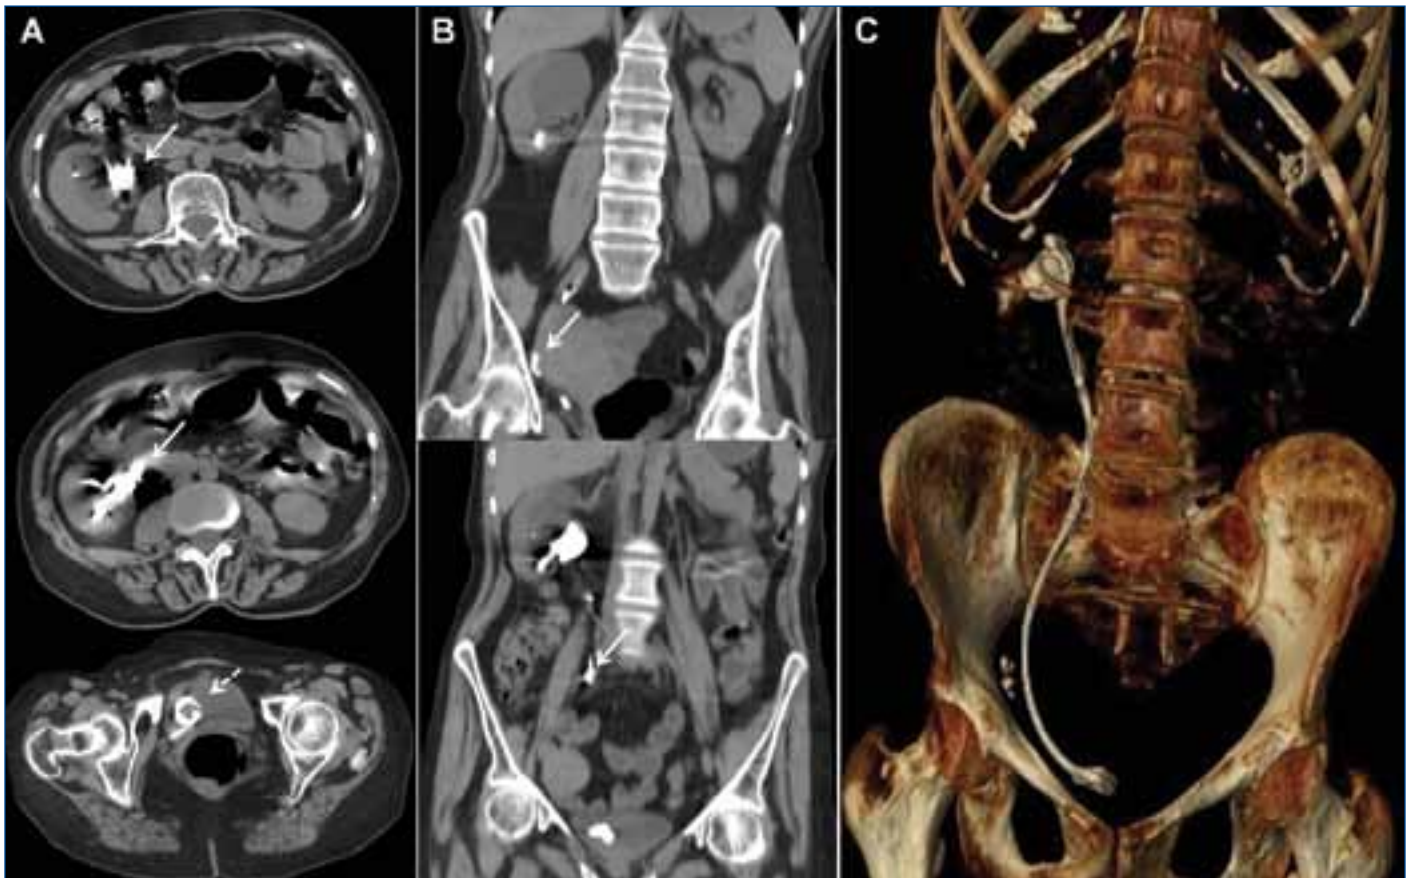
Non-contrast computed tomography accurately evaluate the extent of double J encrustation; A – Axial view depicts significant stone burden associated with the forgotten stent in the kidney and ureteropelvic junction (straight arrow) with less encrustation in the bladder (dashed arrow); B – Coronal view aids evaluation of stent encrustation in the ureter (arrow); C - Volume reconstruction gives a comprehensive understanding of the complete stone burden associated with the stent in all locations of the collecting system.
